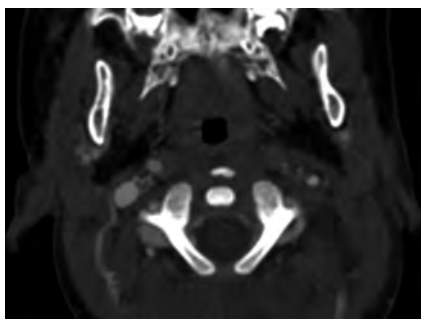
Internal carotid artery injury in patient 6. CTA of the neck demonstrating occlusion of the left internal carotid artery (grade IV injury) at the level of C1 vertebral body in a 1.17-year-old boy who presented neurologically intact after experiencing a witnessed low-speed motor-pedestrian collision.
